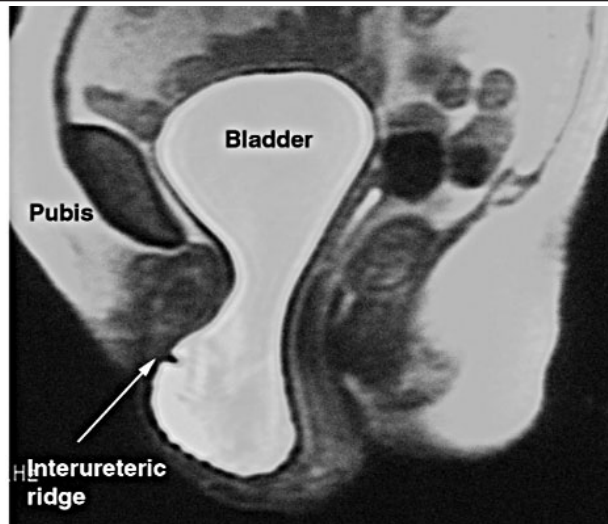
a. MRI: complete urogenital prolapse
